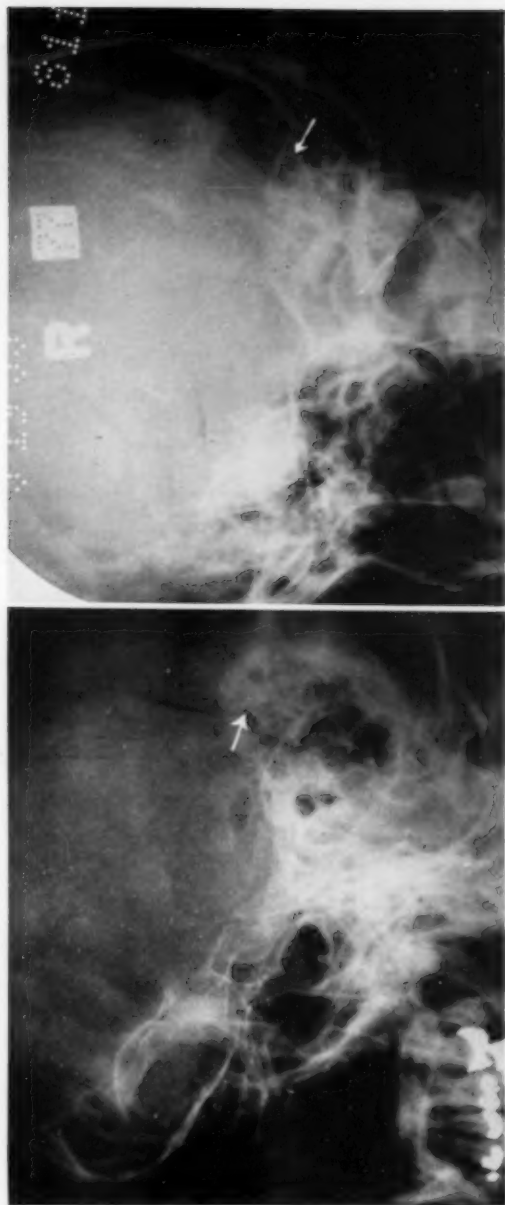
Case 1. Roentgenograms demonstrating the fracture line in the temporal squama extending into the mastoid process indicated by arrows.
